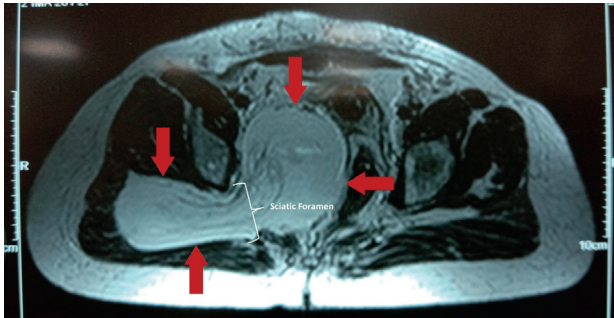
Magnetic resonance imaging of the pelvis (axial section) showing a large well defined intramuscular lesion in the right gluteal region which is seen traversing the sciatic foramen into the pelvis, thus giving it the appearance of a dumbbell (red arrows).
